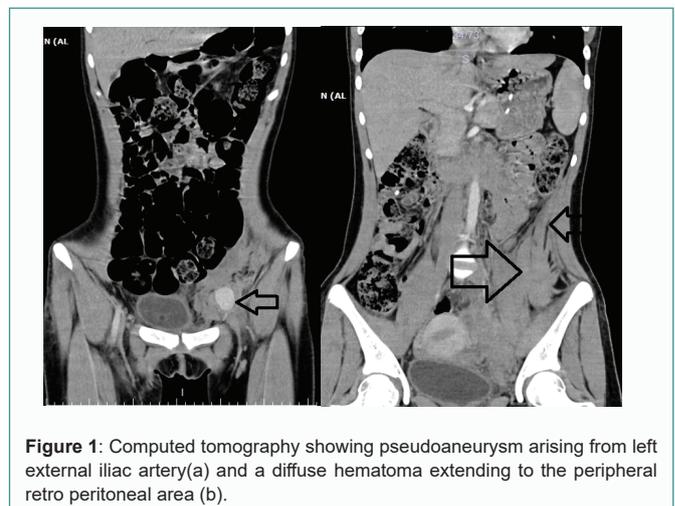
Computed tomography showing pseudoaneurysm arising from left external iliac artery (a) and a diffuse hematoma extending to the peripheral retro peritoneal area (b).
